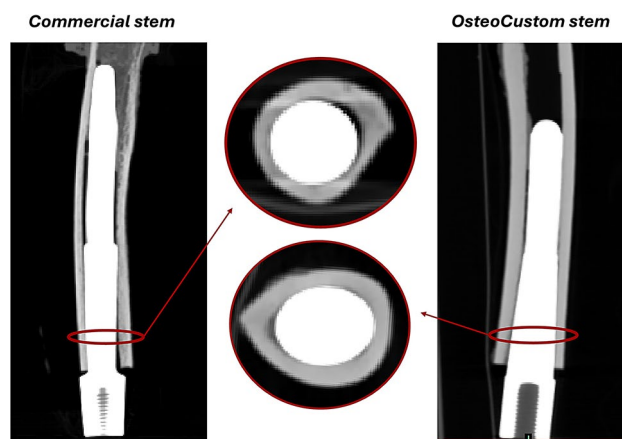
LEFT) CT scan of a typical implantation of the commercial stem (sagittal plane, with a zoom of a distal cross-section showing the contact area of the prosthesis into the bone). RIGHT) CT scan of the contralateral implantation of the OsteoCustom stem (sagittal plane, with a zoom on a distal cross-section)
